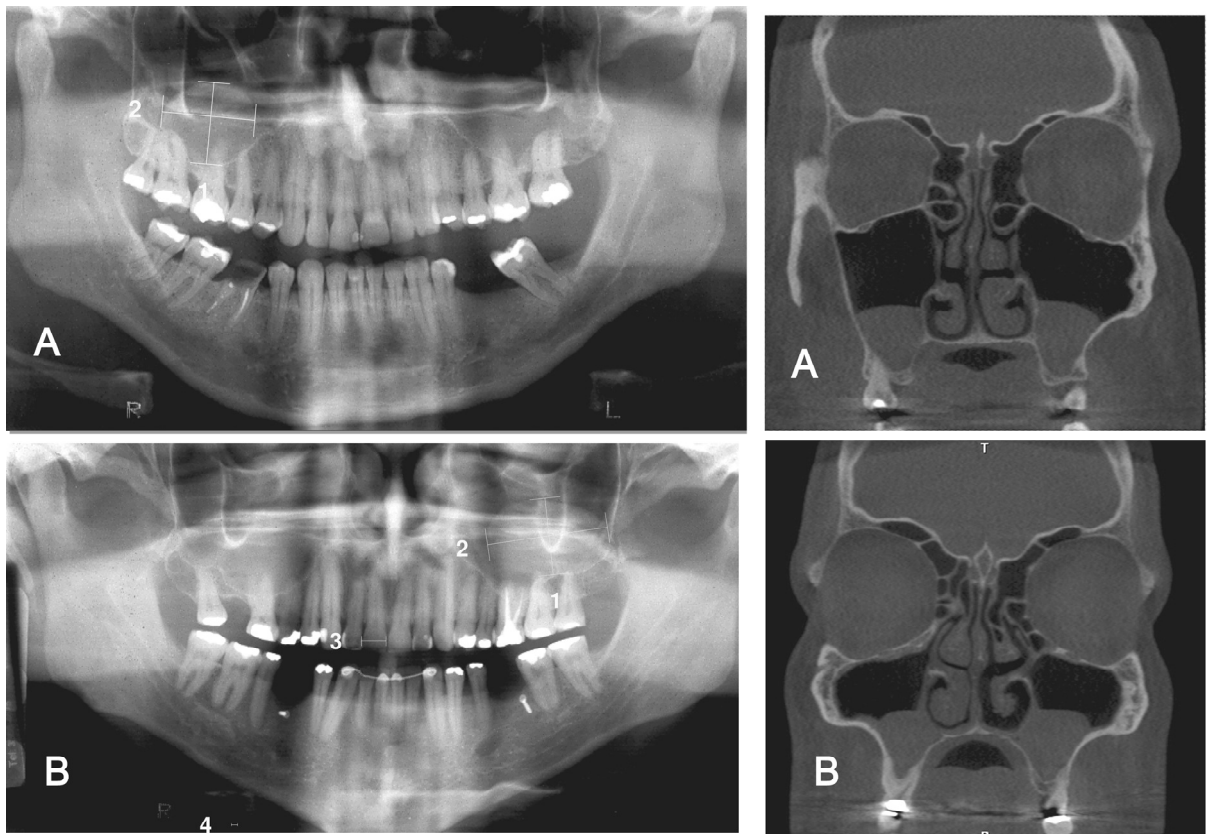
A - Control panoramic radiography with MRCMS in the right side and coronal CBCT reconstruction confirming MRCMS in the right side and showing the presence of another on the left one. B – Control panoramic radiography with CRMSM in the left side and coronal CBCT reconstruction from the same patient with bilateral MRCMS.
